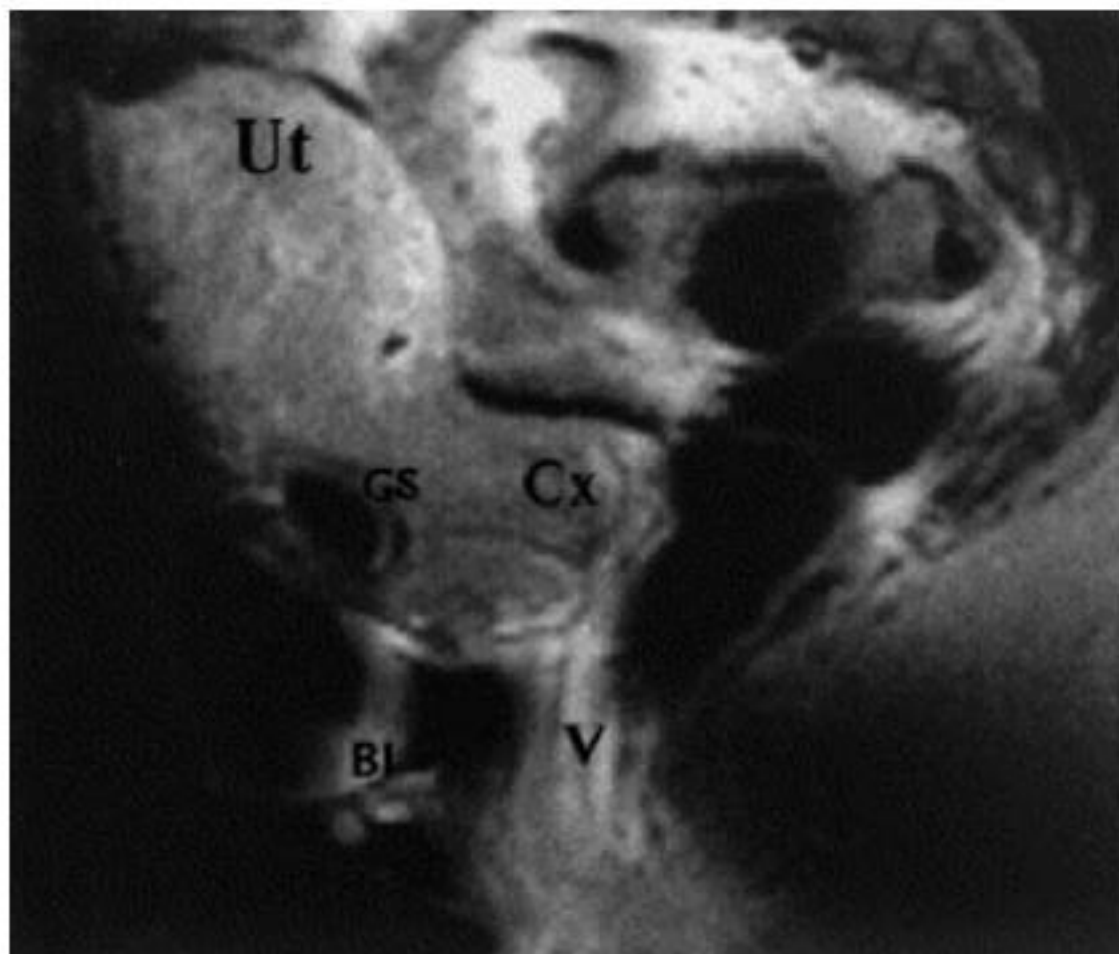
Magnetic resonance image shows implantation of a gestational sac in a caesarean section scar. Reprinted from Shufaro Y and Nadjari M. Implantation of a gestational sac in a caesarean section scar. *Fertil Steril* 2001;75:1217 with permission from American Society for Reproductive Medicine.
